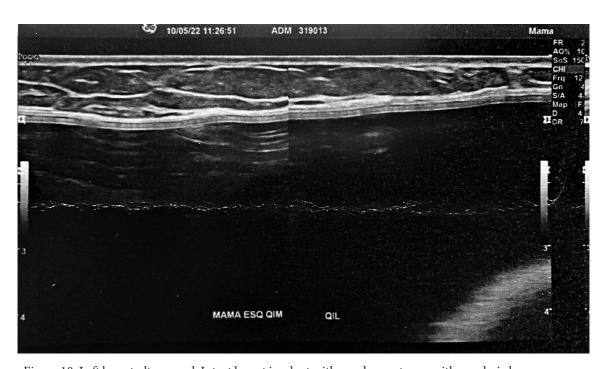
Left breast ultrasound. Intact breast implant with regular contours, with anechoic homogeneous content. Subcutaneous cellular tissue is observed, with no evidence of breast parenchyma.
